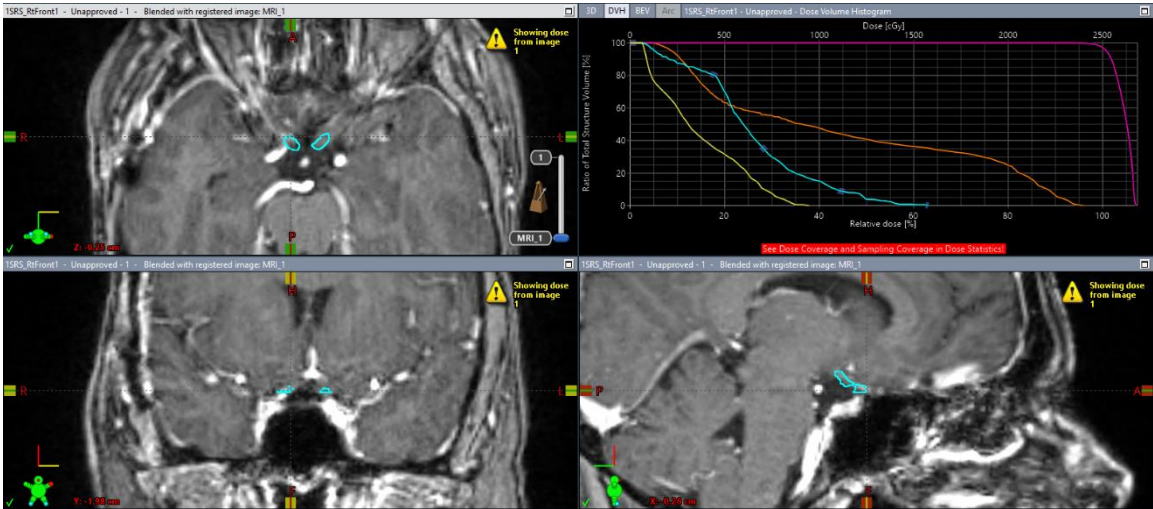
Optic Chiasm, MRI
